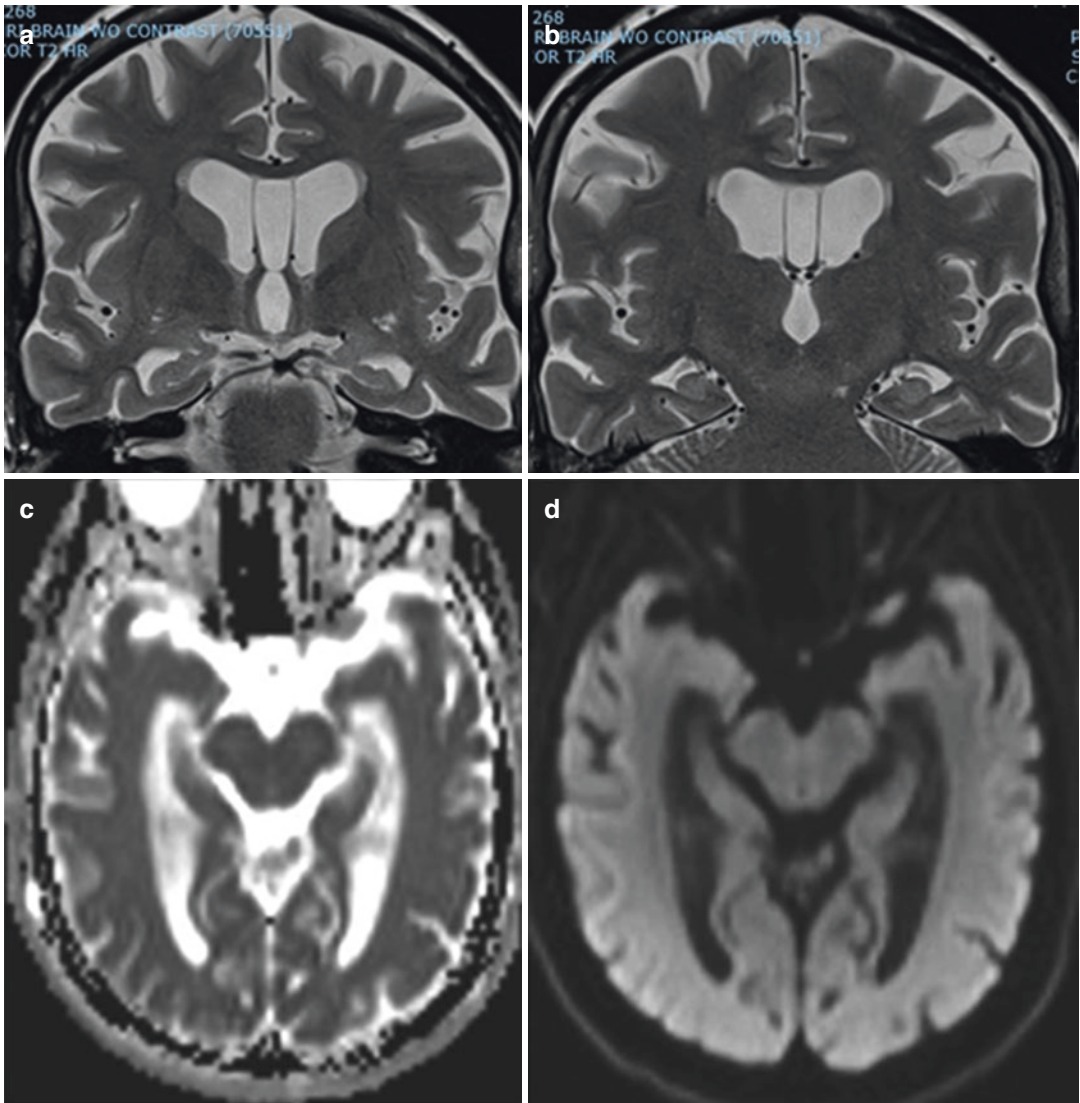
66-year-old female with Alzheimer's dementia. (a, b) Coronal T2 with severe hippocampal atrophy. (c, d) Axial ADC map and trace DWI along the temporal horns
